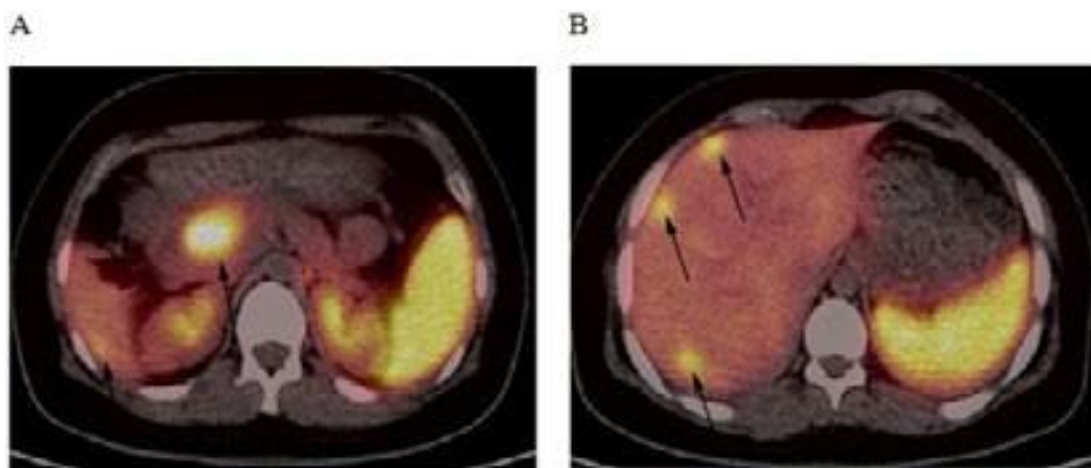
68Ga-DOTATATE PET/CT was performed to reveal an intense Ga-avid pancreatic mass replacing the head of pancreas (A) and multiple Ga-avid lesions in the liver (B), with no additional distant metastases.
